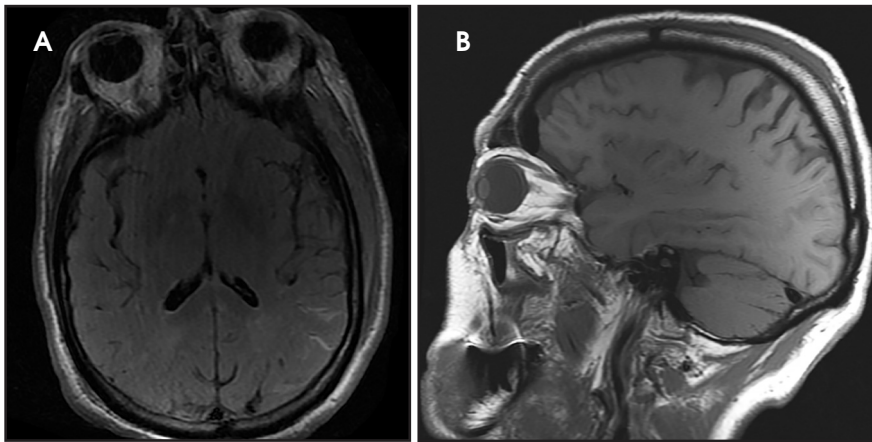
Axial (A) and sagittal (B) FLAIR images with hypointensity in the subarachnoid space consistent with SAH.
